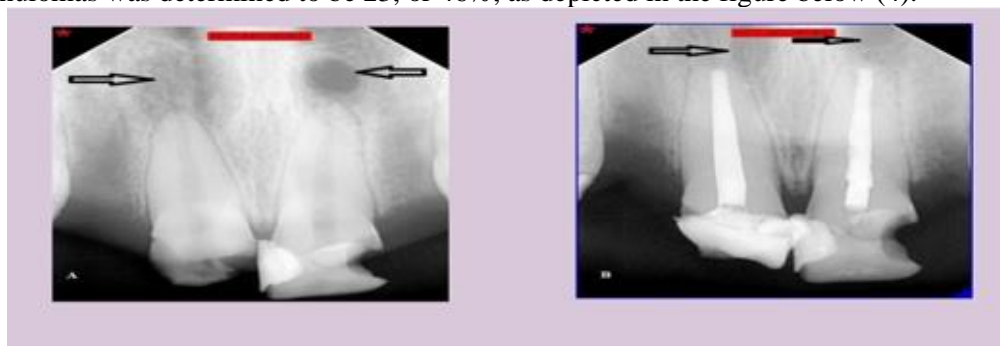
Radiographs of upper right and left central incisors showing periapical lesion
